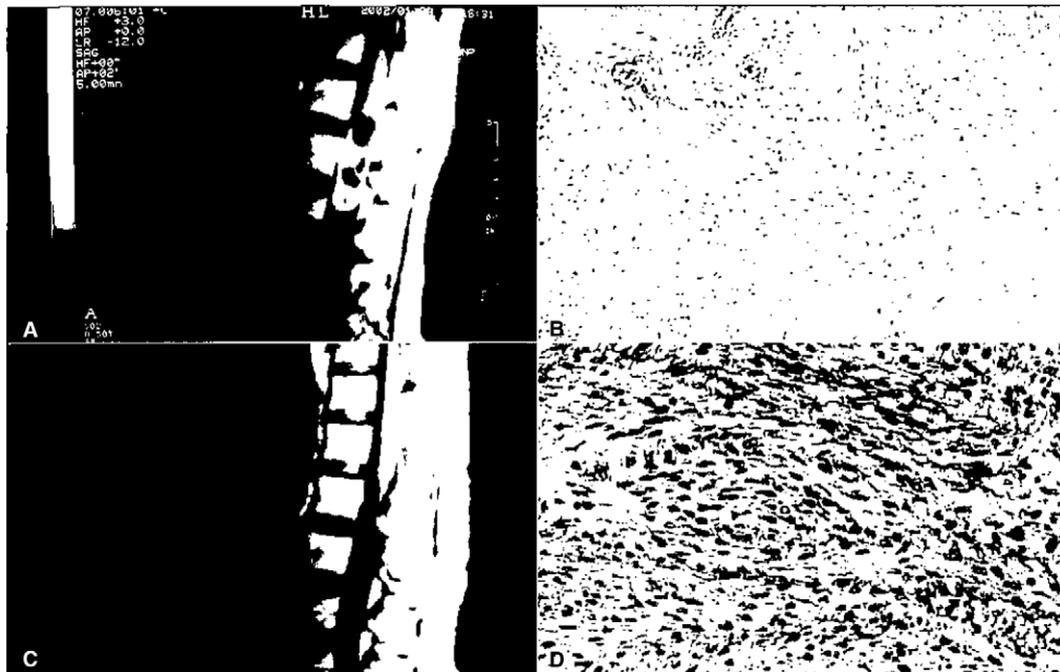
(A) (Left upper) T1-weighted, gadolinium-enhanced preoperative sagittal MRI showing the heterogenous conus medullaris tumour at T12-L2; (C) (Left lower) T1-weighted postoperative, sagittal MRI showing a small amount of residual tumour; (B) (Upper right) On the H & E examination the tumour is cellular in some areas and oedematous in others. The tumour cells have a rounded elliptical nucleus and formed bunches. Hyalinisation is seen around some vessels (×200); (D) (Lower right) Higher power view (×400).
